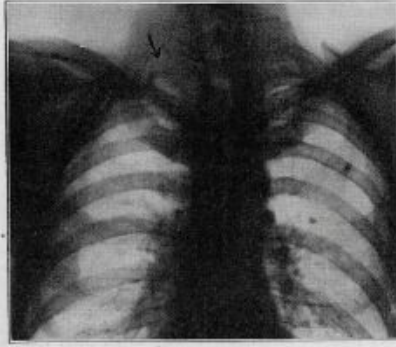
(case 4).—Roentgenogram of the chest, showing slight increase in density in the extreme right apex and slight erosion of the second and third ribs. The neck of the second is involved but not the transverse process.
